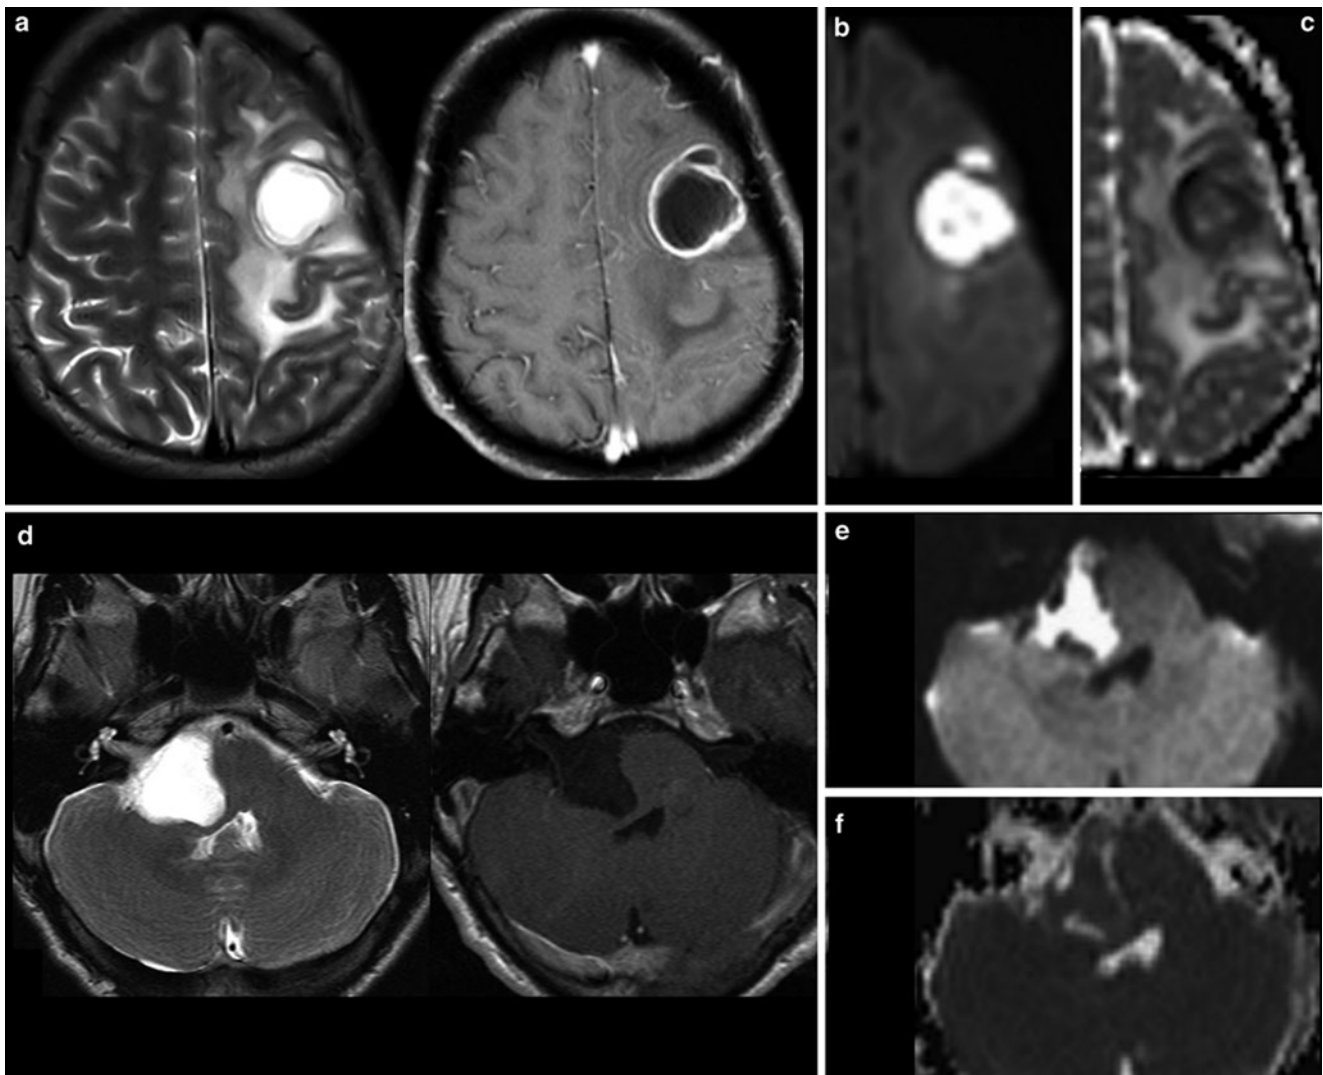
Very hyperintense DWI lesions with corresponding lower ADC values. Ring-enhancing lesion with edema in patient with lung cancer (a). Very high DWI signal (b) with lower ADC values (c) were highly suspicious for an abscess, which was confirmed by stereotactic puncture. Also note the hypointense signal of the capsule in T2WI (a). The
